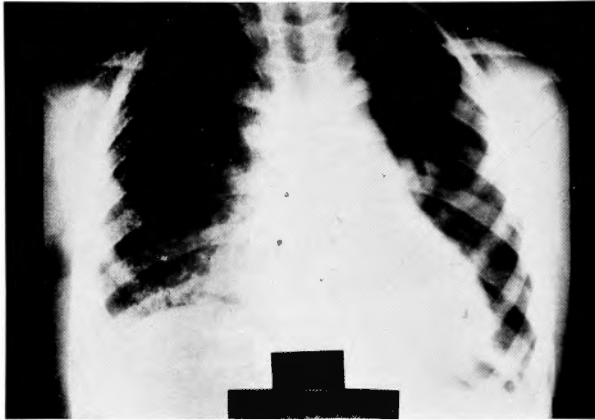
X-ray findings of chest at discharge from the hospital.
